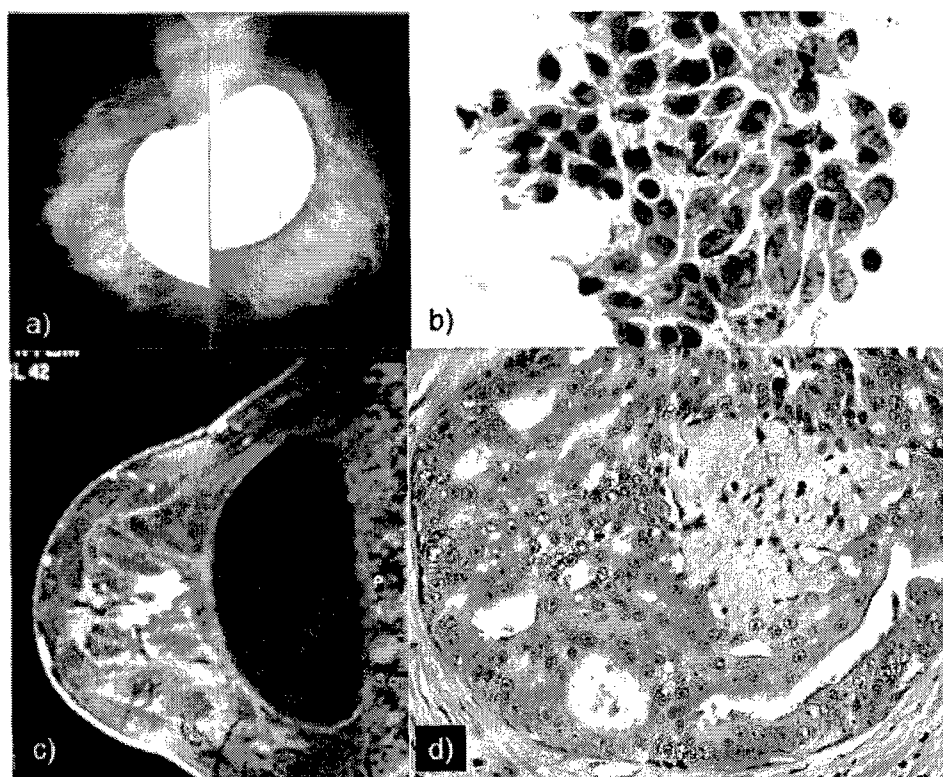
An interesting patient. (a) A screening mammogram revealed a suspicious cluster of microcalcifications in the right breast. The left breast was interpreted as normal. (b) Nipple duct lavage of the left breast at the time of right mastectomy returned markedly atypical cells. (c) This left breast magnetic resonance image demonstrates three areas of abnormal enhancement. (d) A subsequent left total mastectomy revealed 10 cm of ductal carcinoma in situ.
